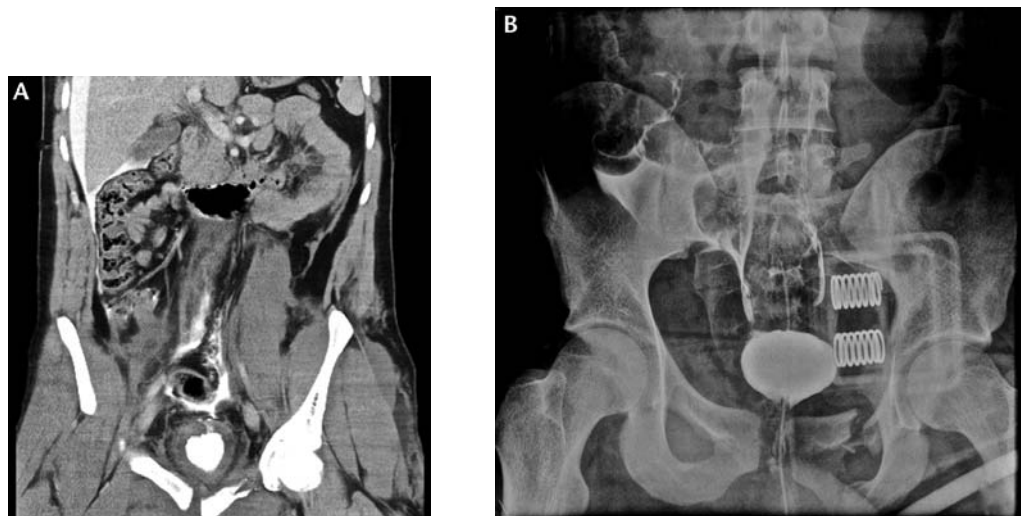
(A) Intraperitoneal (IP) contrast on computed tomography image of the abdomen. (B) IP contrast detected on retrograde cystogram.
